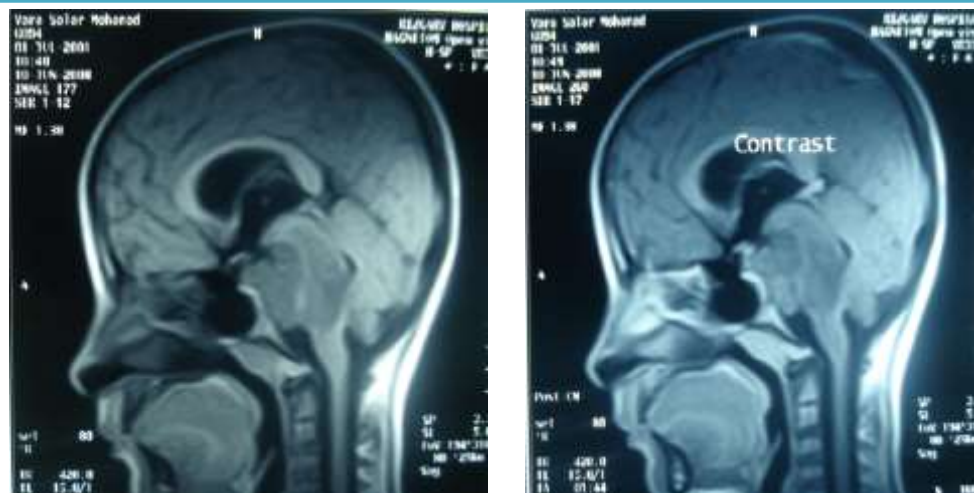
MRI in sagittal T1WI pre & post contrast shows brain stem glioma
